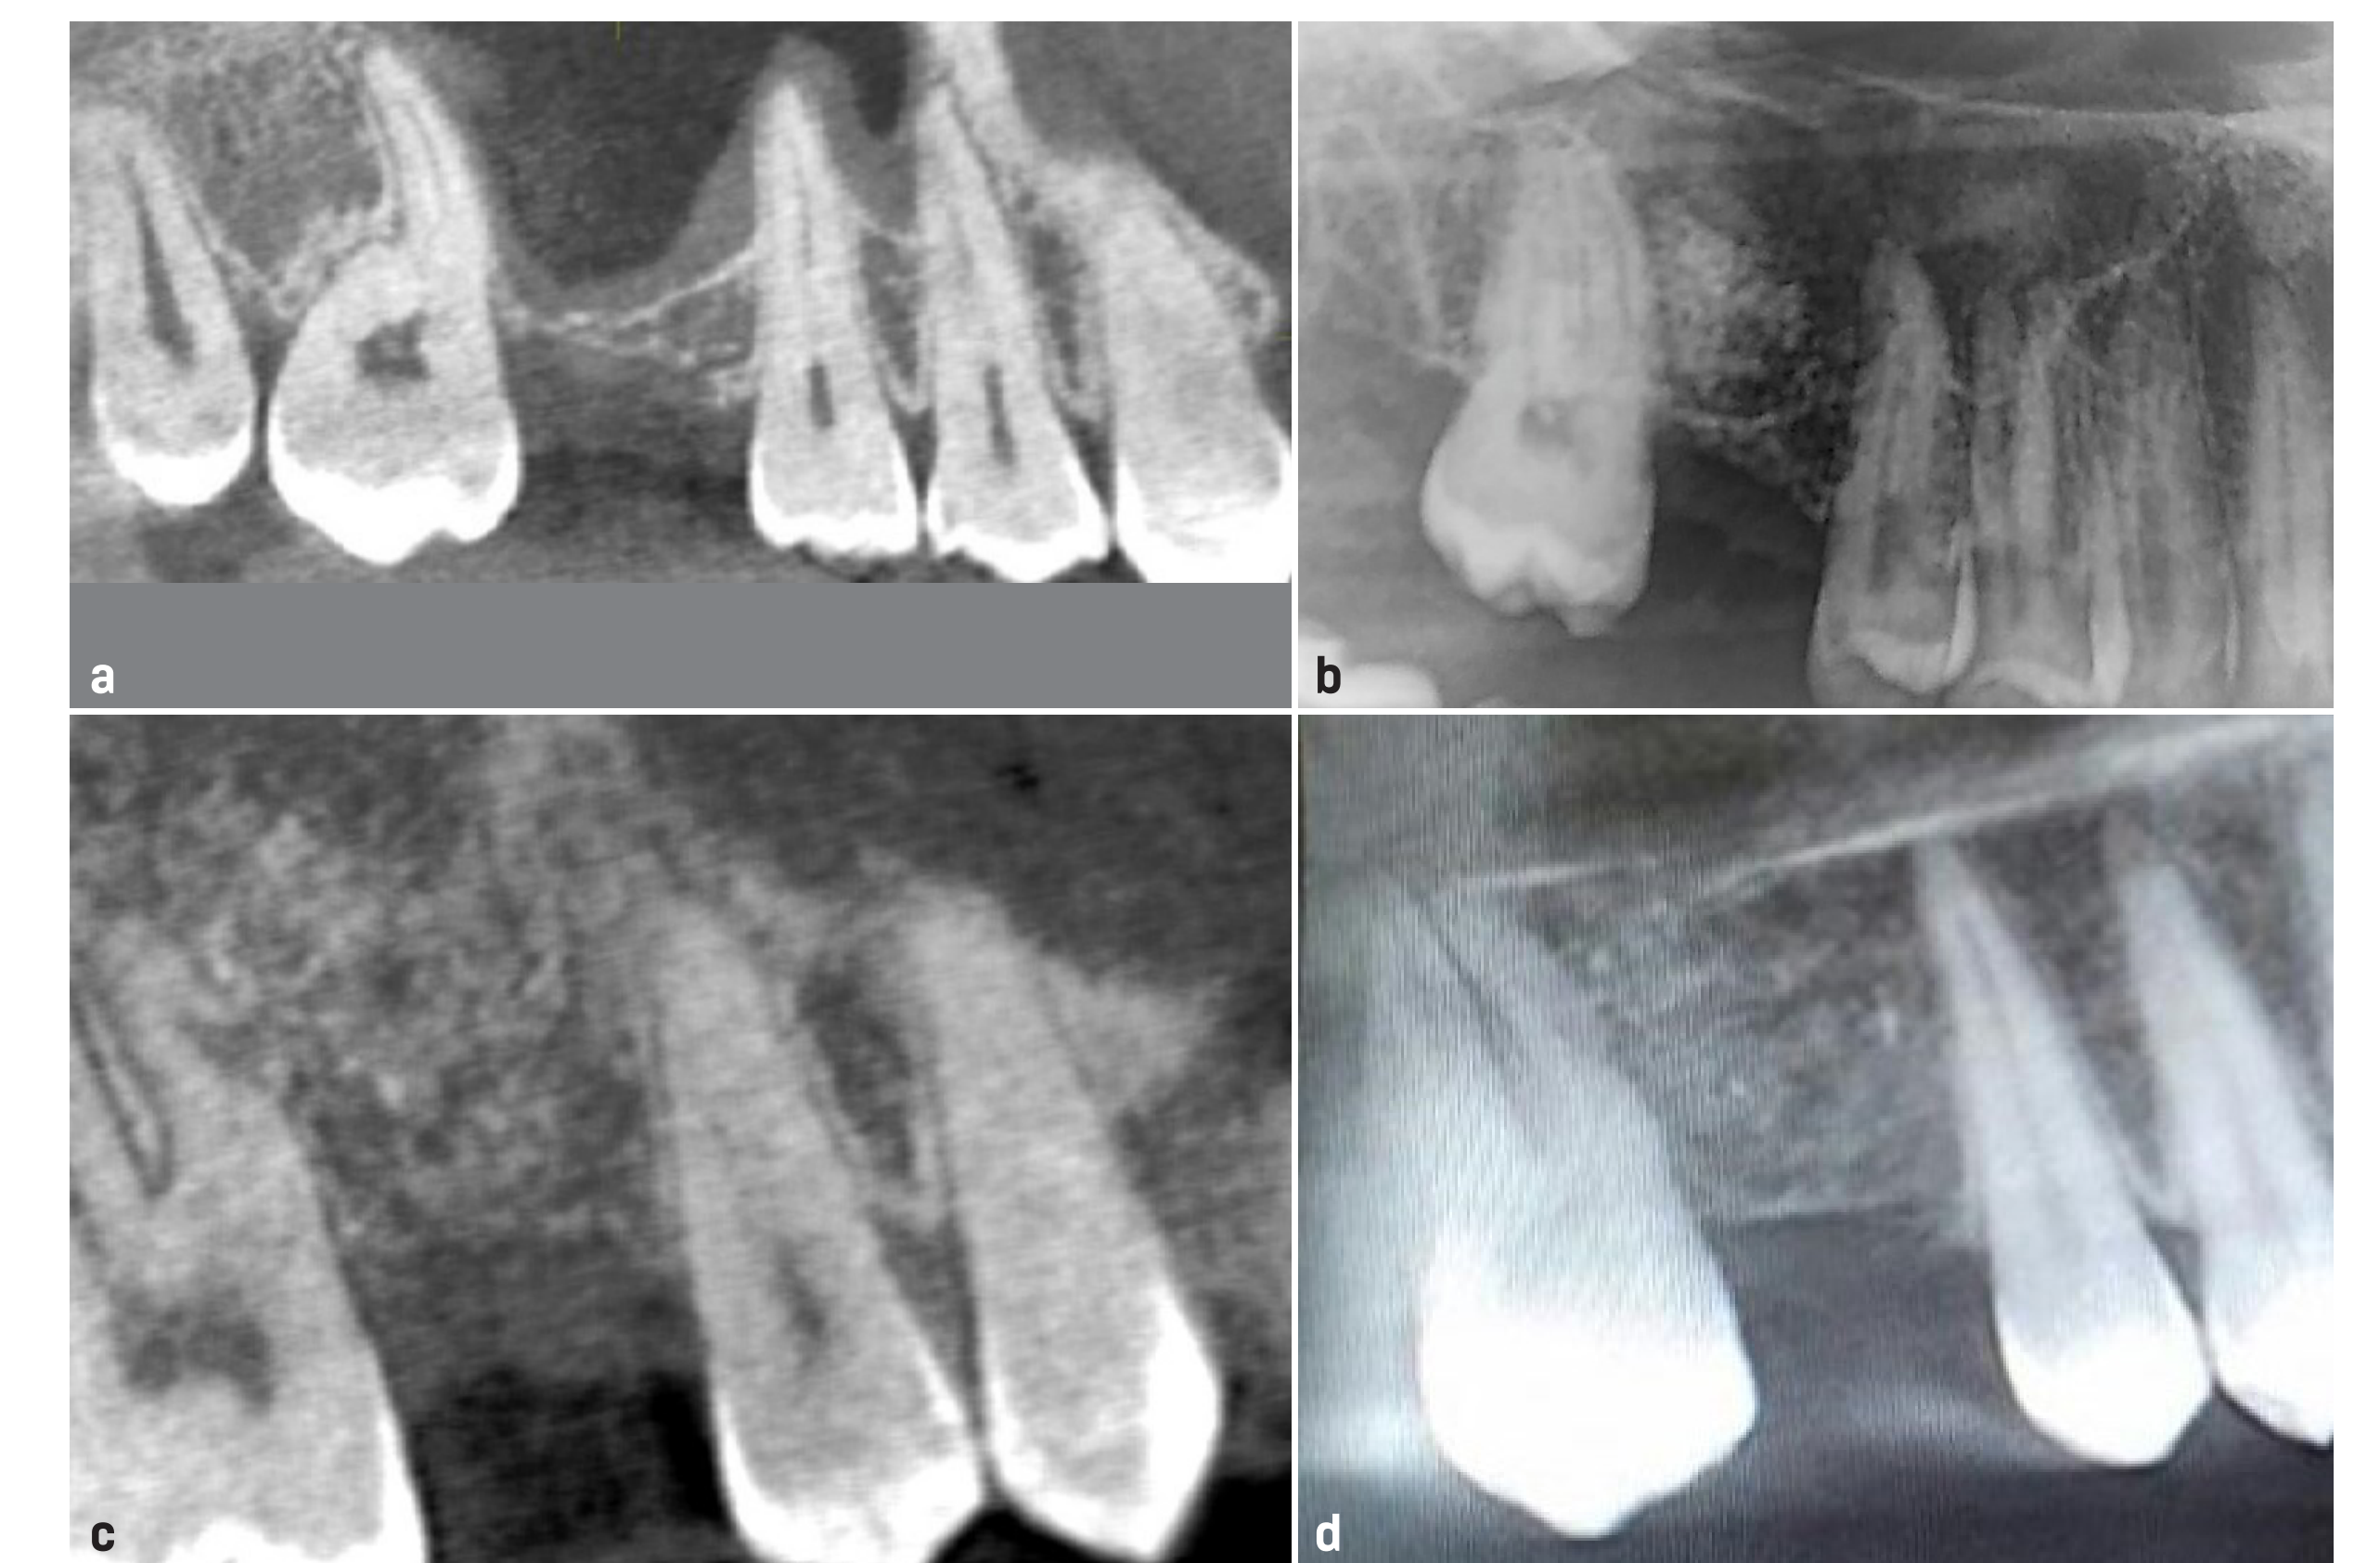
CBCT panoramic image before (a) and after 2 months (b) and 4 months (c), (d) 5 months.
